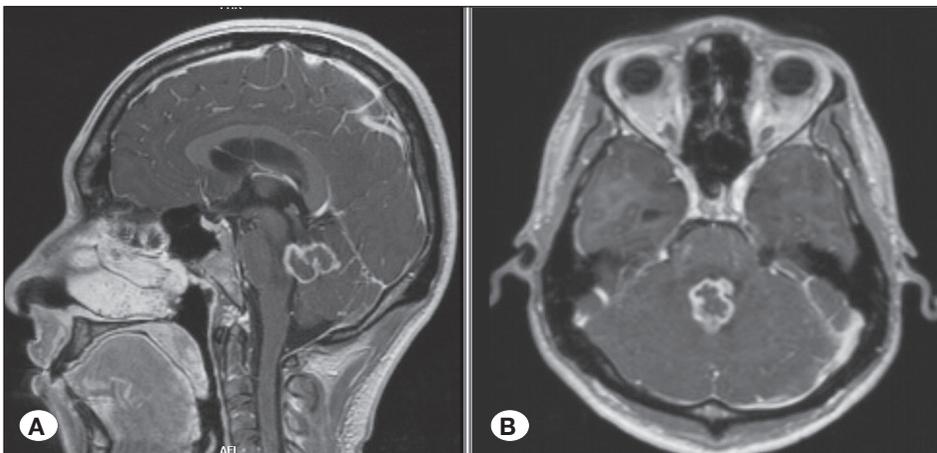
Brain MRI with contrast (A: Sagittal; B: Axial) revealed a lobulated lesion with peripheral contrast enhancement involving the roof of the fourth ventricle and the pontine tegmentum.
